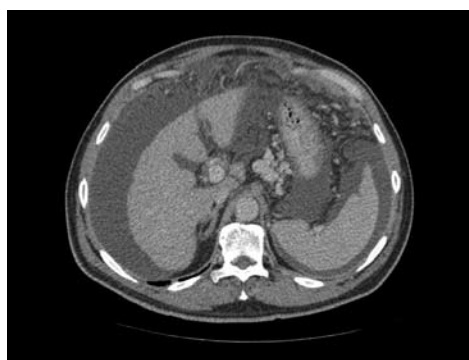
(right): CT scan of a patient with end stage liver disease due to HCV demonstrating a shrunken liver, splenomegaly and ascites. The patient was treated with liver transplantation.
